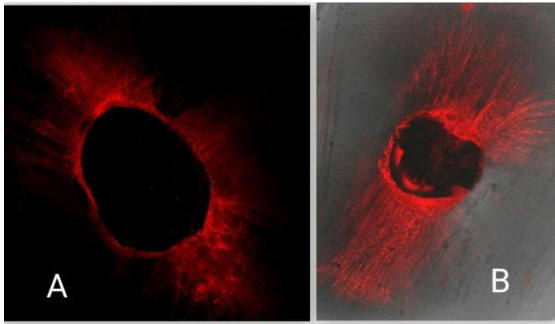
Sealer penetration in coronal (A) and apical (B) segments of ultrasonic (UA) group.
